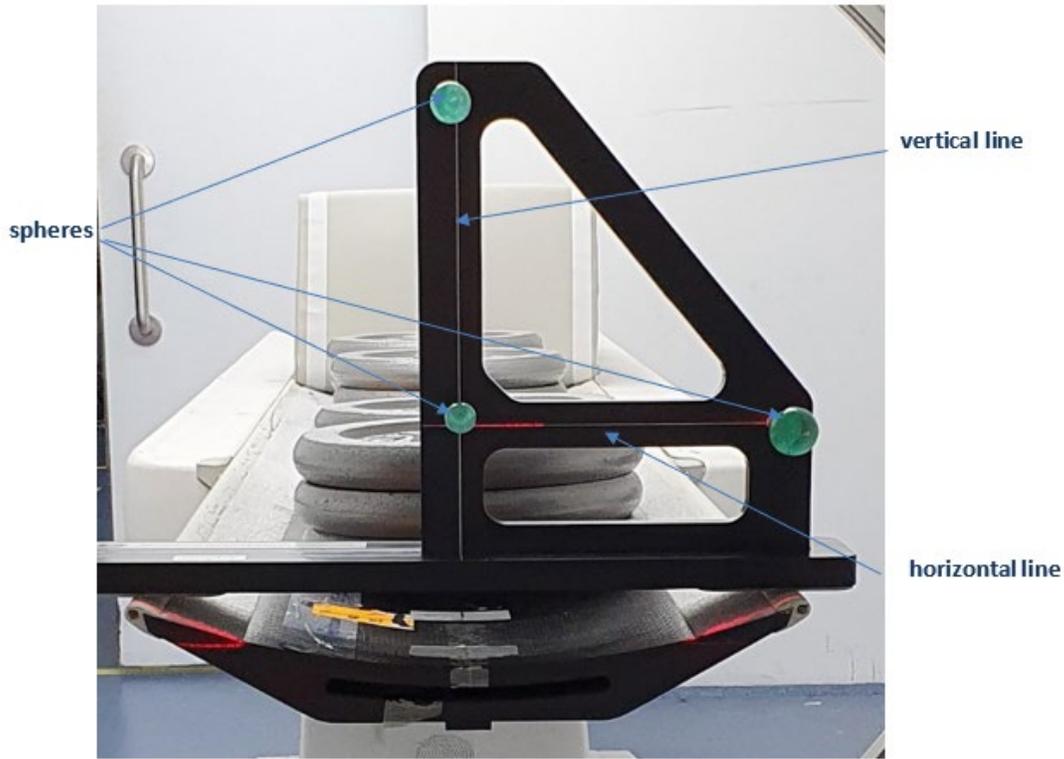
PET-CT co-registration holder. The table pad should be removed during the measurement.
